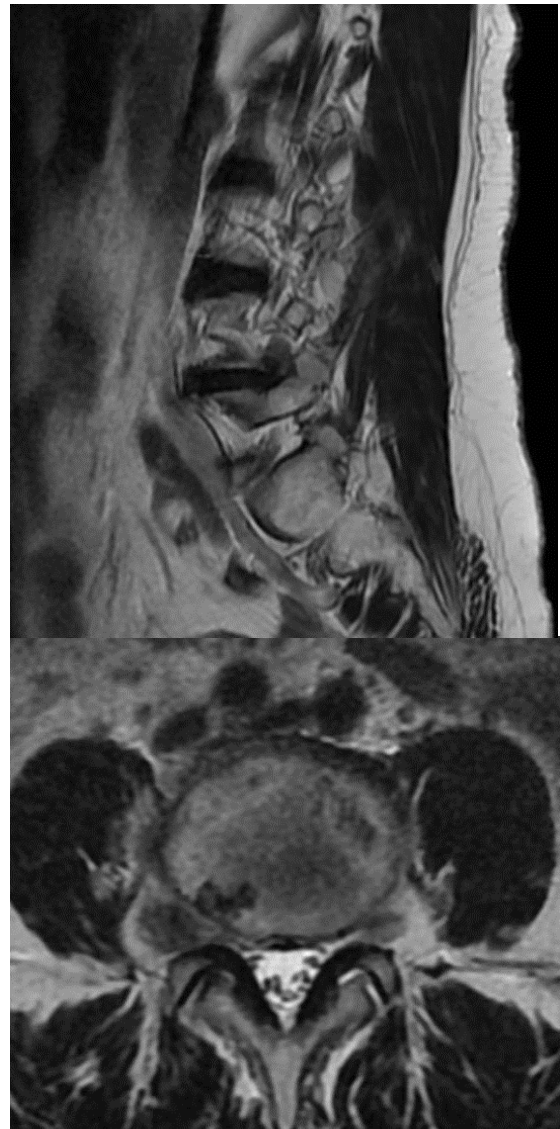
a.b. Preoperative sagittal and axial magnetic resonance images of a 53-year-old female patient with right L4-5 far lateral disc herniation.
